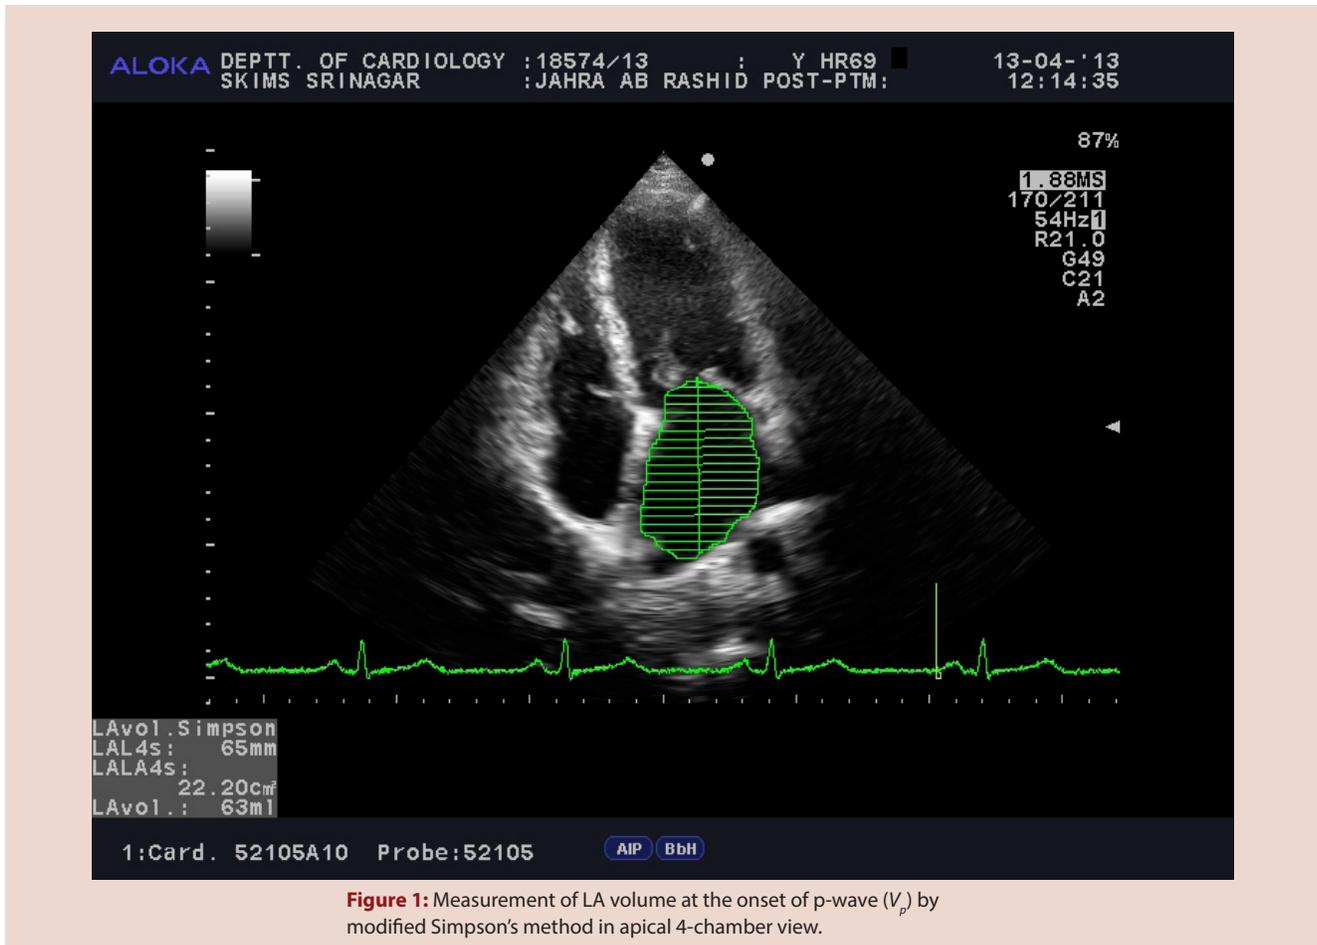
Measurement of LA volume at the onset of p-wave (V_p) by modified Simpson's method in apical 4-chamber view.
